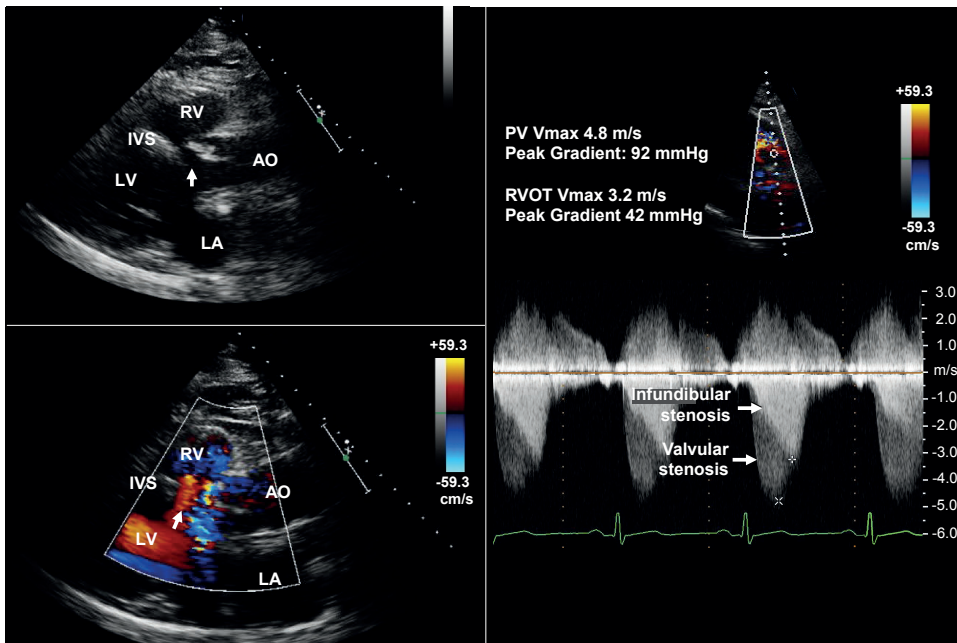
Parasternal long-axis echocardiographic view
